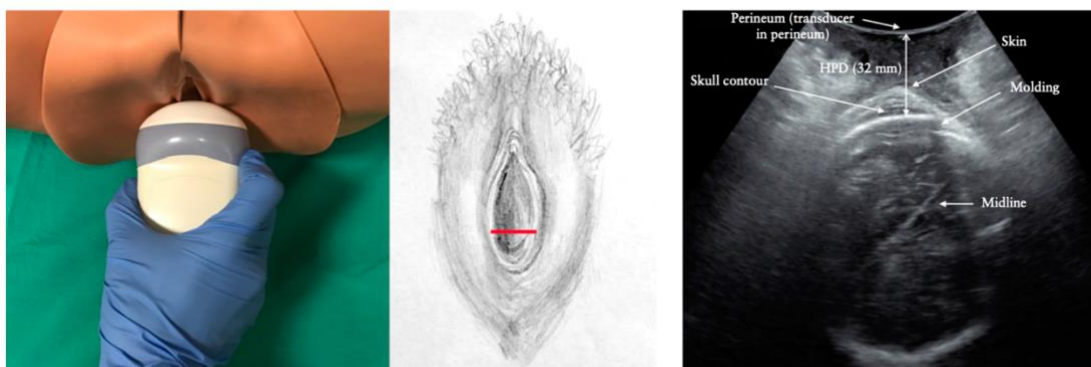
Measurement of head- perineum distance. *Showing placement of transducer and how distance is measured (adapted from ISUOG Practice Guidelines: intrapartum ultrasound)* ³
